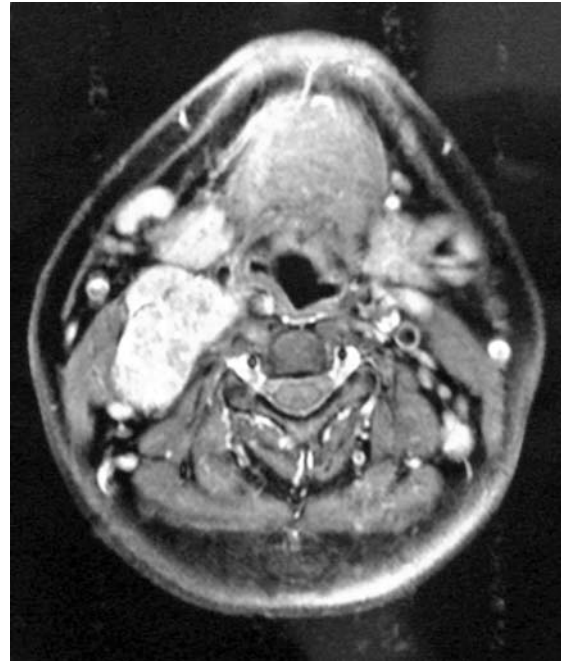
Axial T2-W MR image shows that the parapharyngeal space is obliterated, pushing the tracheal wall medially, which may explain the patient's symptom of occasional dyspnoea.
